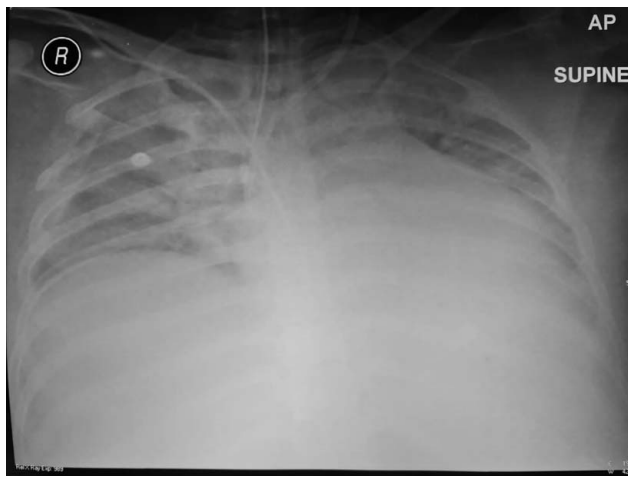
Chest radiograph at the sixth day of hospitalization.
